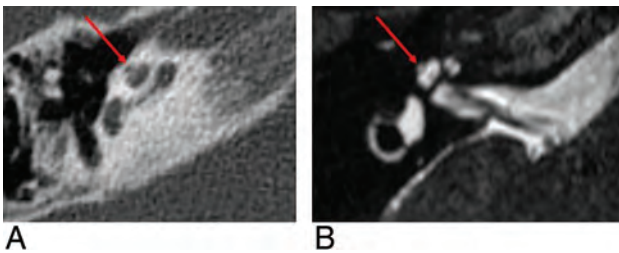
A thorny apical turn in a patient with *SIX1*-BOR. The apical turn of the cochlea appears as a short, protuberant, thorny tip, as seen on CT (A) and MR imaging (B).
